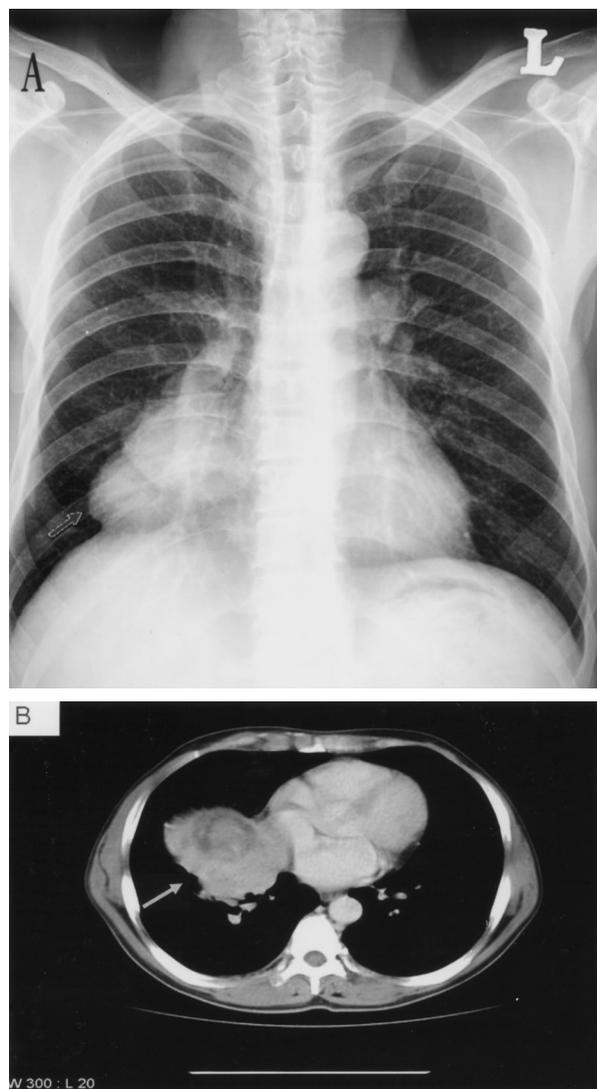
(A) Chest X-ray PA view showing RML mass (arrow); (B) Mass compressing cardiac chamber (arrow)
